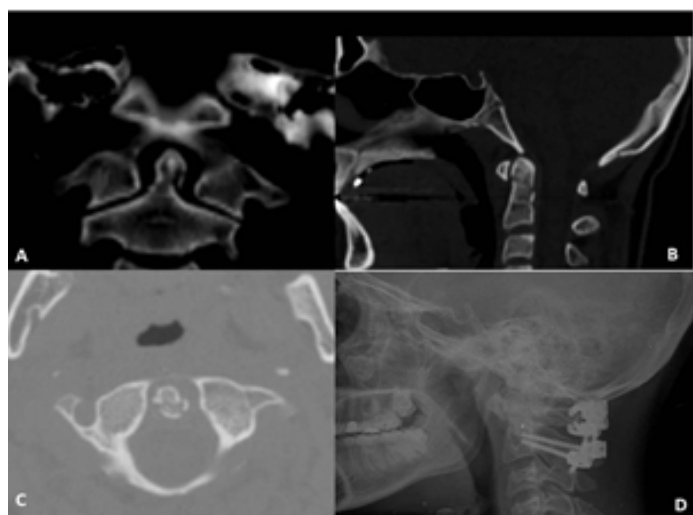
19/M motorcycle accident, neurological evaluation intact, Suboccipital and Neck pain, odontoid fracture (motorcycle accidents): preoperative coronal, sagittal and axial CT images (A, B, C) postoperative 12-month lateral radiography (D)
